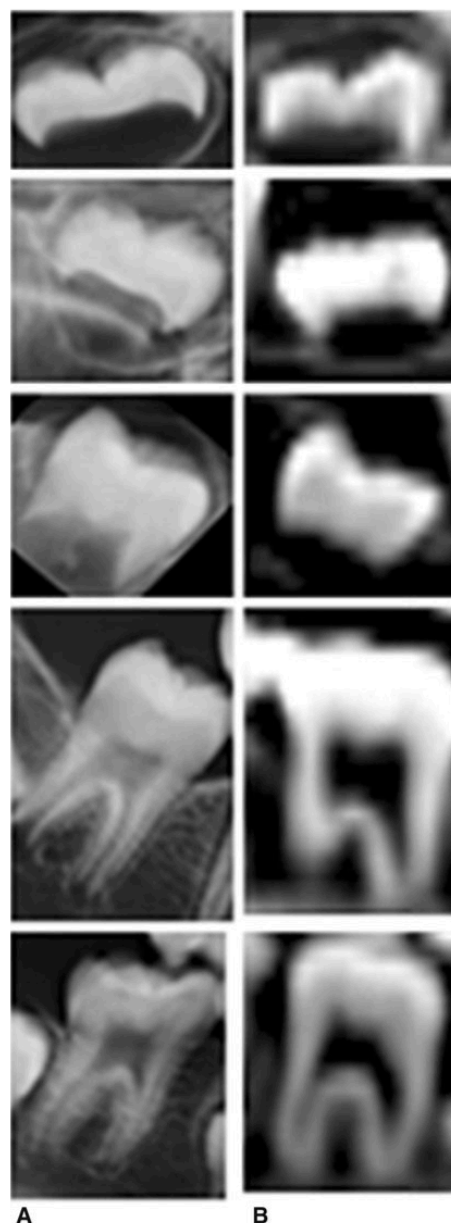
a Radiographic images traditionally used for comparison for the Demirjian method [53]. b MDCT images created using OsiriX software package. It is evident from these images that a sufficient amount of detail is achieved using MDCT to carry out this technique successfully
